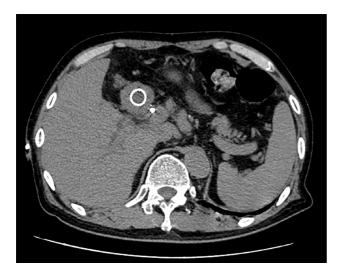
A computed tomography scan conducted before discharge showed that the splenic hematoma had disappeared.
